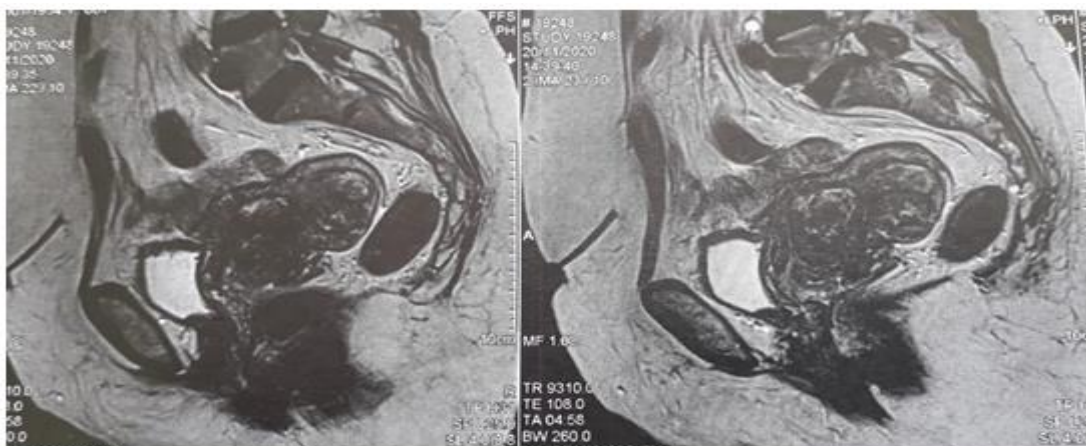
MRI Images showing uterus with two formations, one anterior isthmic and the other higher on the posterior wall, both heterogeneously enhanced after injection.
